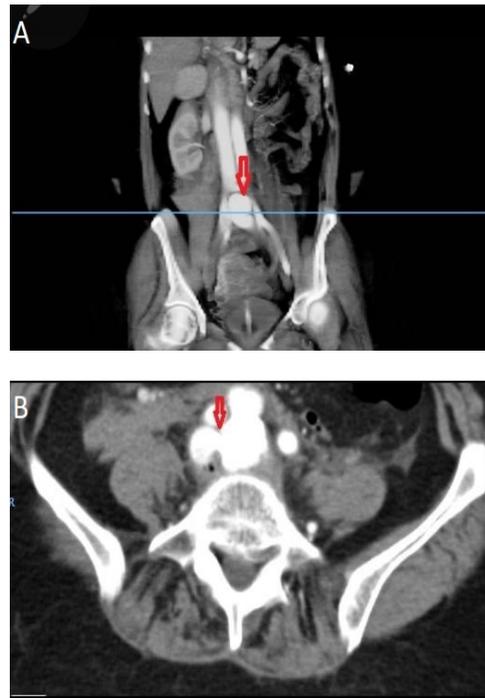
Immediate post-discectomy CTA, arterial phase, (A) showed coronal view with red arrow pointing at pseudo-aneurysm formation. (B) showed axial cuts with red arrow pointing at fistulous communications between iliac vessels and opacifications of veins due to shedding of arterial blood into venous system.
